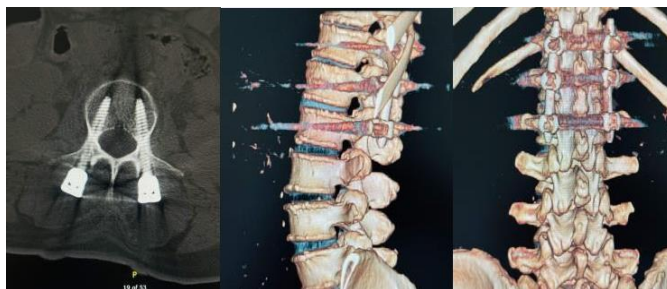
Post operative plain X-ray shows the correct position of the pediclescrews.
